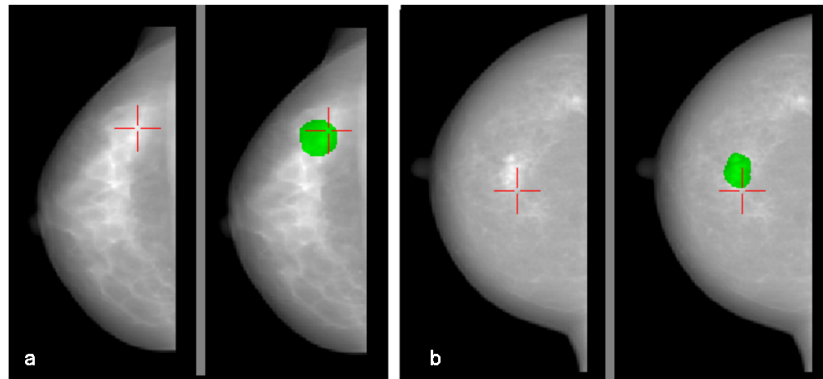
Registration results on 2 patients. For each case, the left image shows the real mammogram with the centre of mass of the MR annotation after alignment (red cross). The right image in each pair shows again the real mammogram, but as well as the projected MR annotation, the mask of the X-ray annotation is also shown in green.(a) p1 (error: $7.8mm$) and (b) p2 (error: $14mm$).
